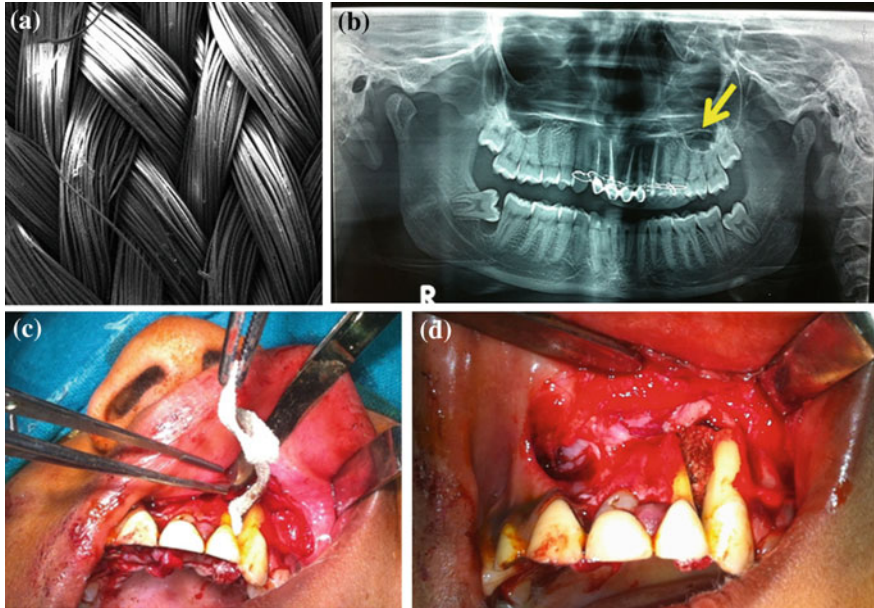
Application of silk braid: a SEM image of silk braids, b Dental X-Ray—Orthopantomogram) arrow is indicating the defect site, c, d Intra-operative images for implantation of silk braided fabric
